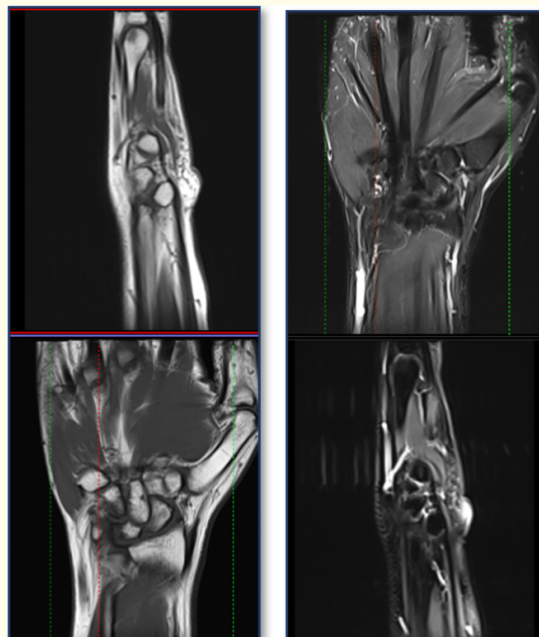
An MRI scan revealed abnormal signal intensity in the pisotriquetral ligament and non-anatomical reduction of the pisiform.
